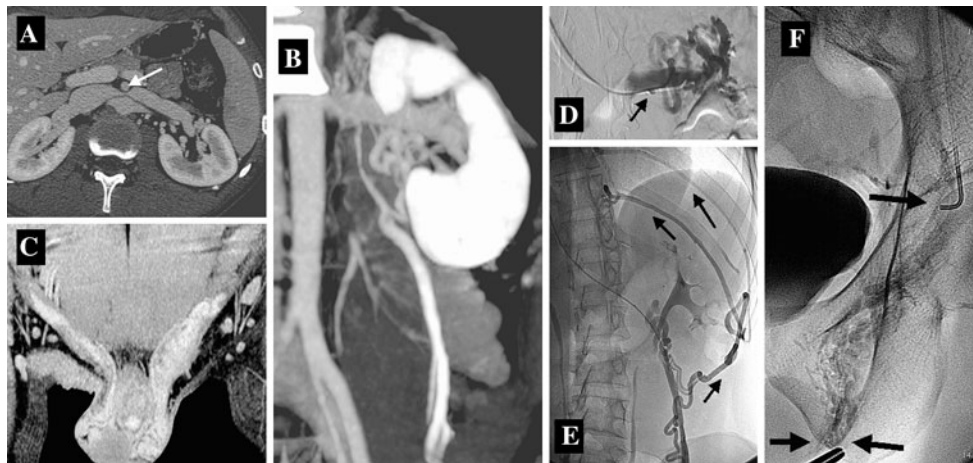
MDCT-A evaluation of persistent postsurgical (inguinal ligation) grade IV LVA and its percutaneous treatment. A Axial CTA shows severe aorto-mesenteric compression of the LRV (*white arrow*). B 3D maximum-intensity projection showing large perirenal varices and dilated LSV. C 3D-maximum intensity projection (MIP) showing large left inguinal and scrotal PP. Note that the right PP is also dilated because of hemodynamic transscrotal overload. D Left renal phlebography by the right brachial approach was performed
